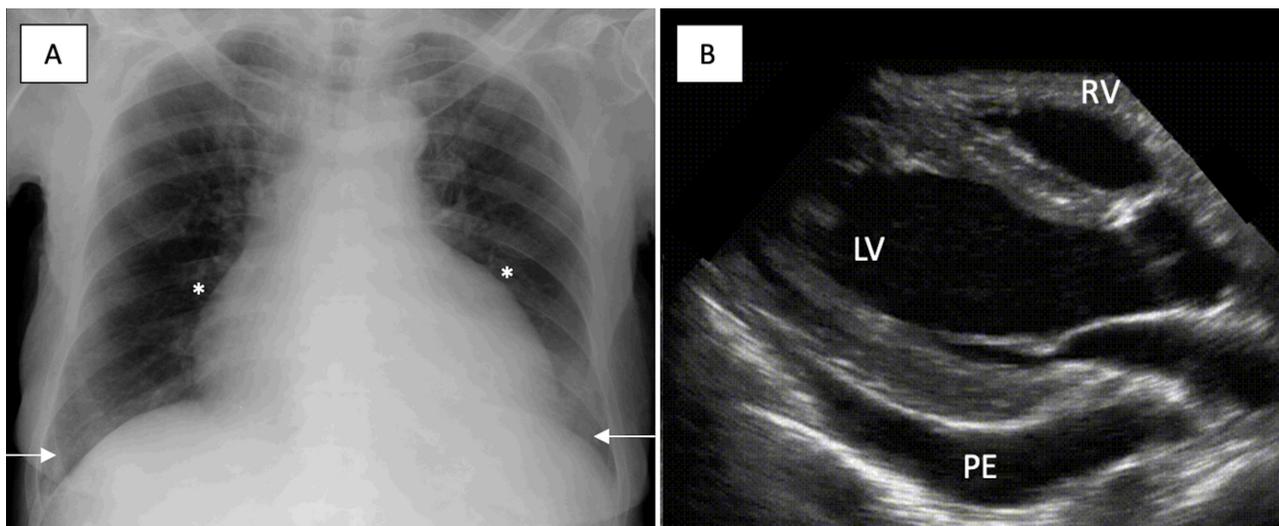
A. Chest X-ray at admission. Increased cardiothoracic ratio (asterisks) and bilateral pleural effusion (white arrows). B. Transthoracic echocardiogram at admission. PE – Pericardial effusion. LV – Left ventricle. RV – Right ventricle.
